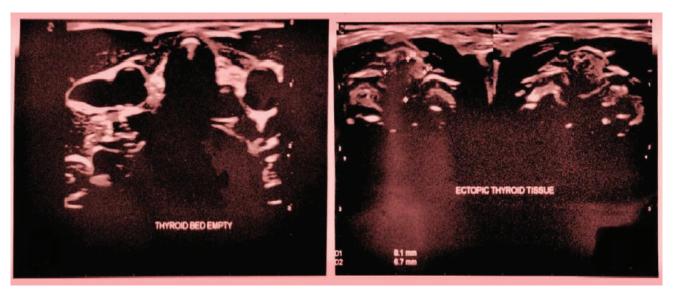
High resolution ultrasound images of neck of an 11 years old girl with congenital hypothyroidism, showing no thyroid tissue in the thyroid bed but a 8X7mm sized area resembling thyroid tissue posterior to the base of the tongue.
